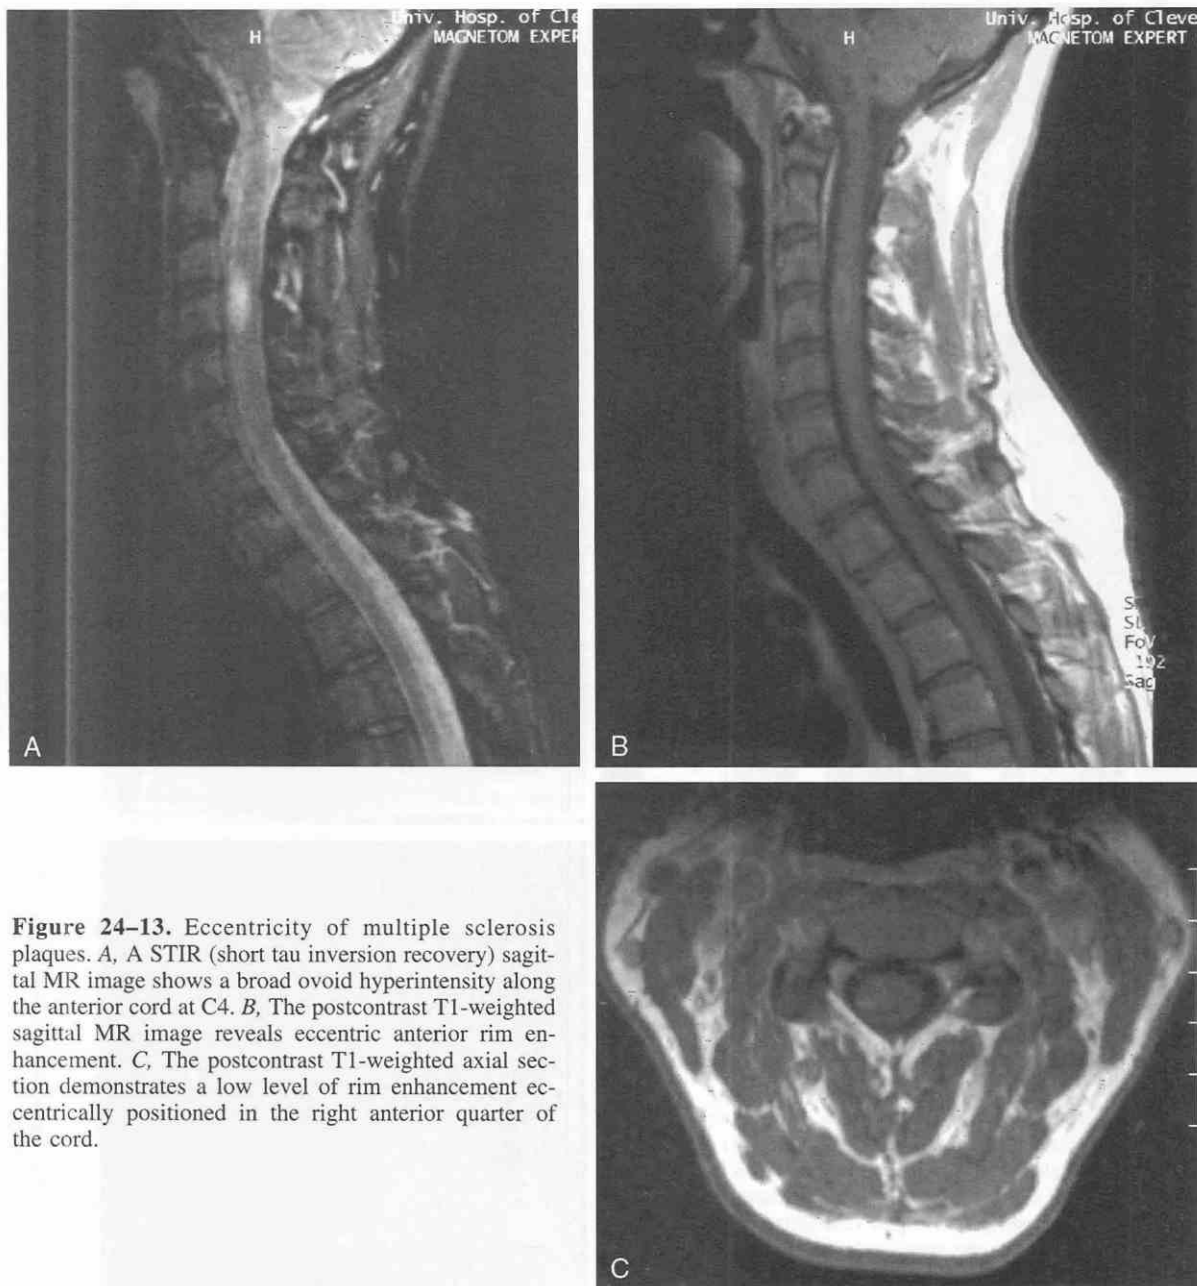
Eccentricity of multiple sclerosis plaques. *A*, A STIR (short tau inversion recovery) sagittal MR image shows a broad ovoid hyperintensity along the anterior cord at C4. *B*, The postcontrast T1-weighted sagittal MR image reveals eccentric anterior rim enhancement. *C*, The postcontrast T1-weighted axial section demonstrates a low level of rim enhancement eccentrically positioned in the right anterior quarter of the cord.
